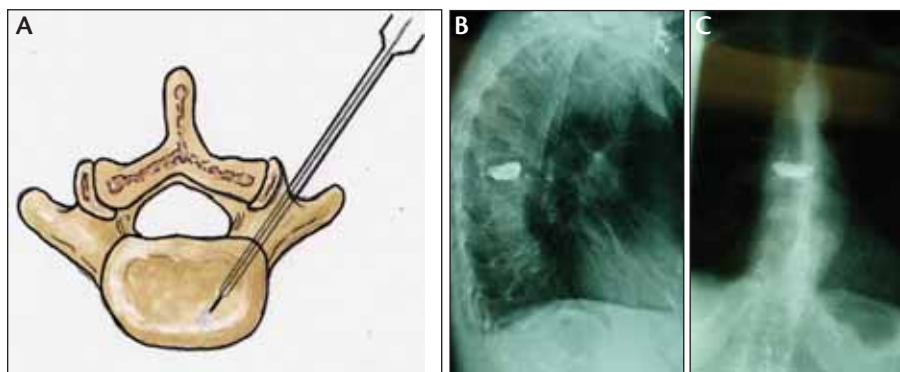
Cannulation of the pedicle with Jamshidi needle (MedSurge Inc., Rochester, MN) (A) with lateral (B) and anteroposterior (C) x-ray views after vertebroplasty for a thoracic compression fracture.
